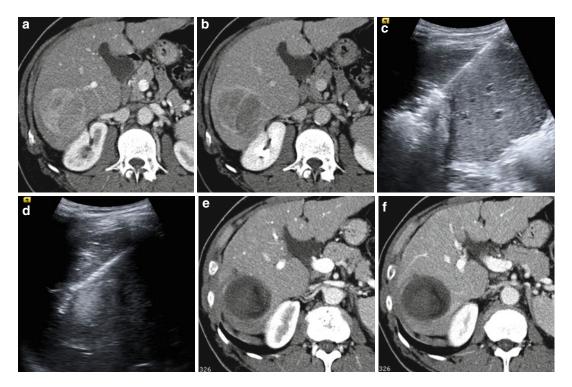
Combined ethanol injection and RF ablation of HCC.* Pretreatment contrast-enhanced CT shows the lesion as a hypervascular nodule (a) in the arterial phase with hypodense appearance in portal-venous phase (b). Under ultrasound guidance, ethanol injection (c) followed by RF ablation with expandable needle (d) is performed.
